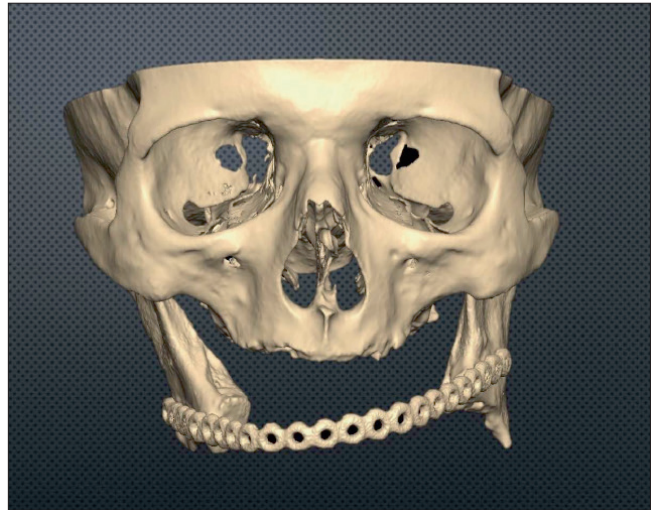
3D model of CT showing bilateral rami anti-version and rotation without condyle displacement.
